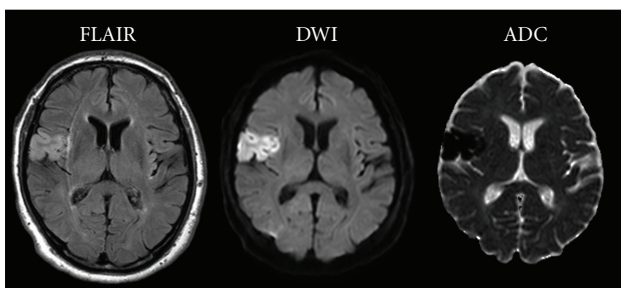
Case 2: follow-up MRI with FLAIR, DWI, and ADC showing an established infarction in the right frontal lobe matching the CTP-delineated ischemic core.
